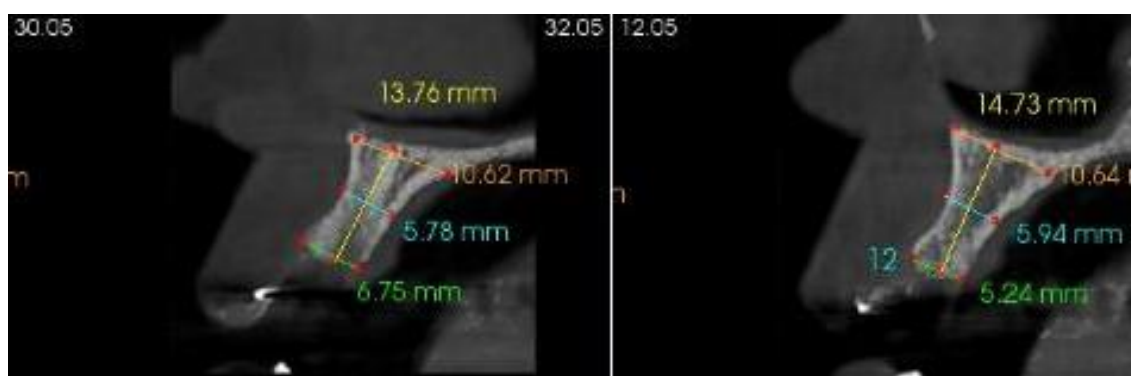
Pre operation CBCT
